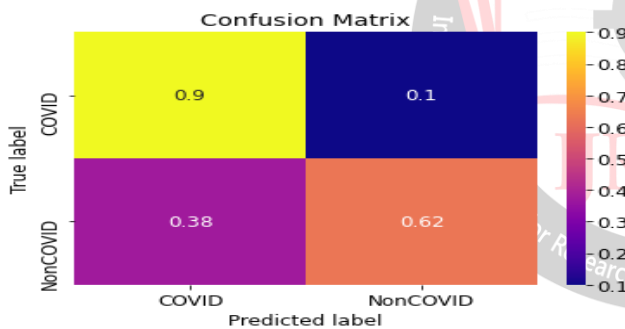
Confusion Matrix of Inception model for CT-Scan images
